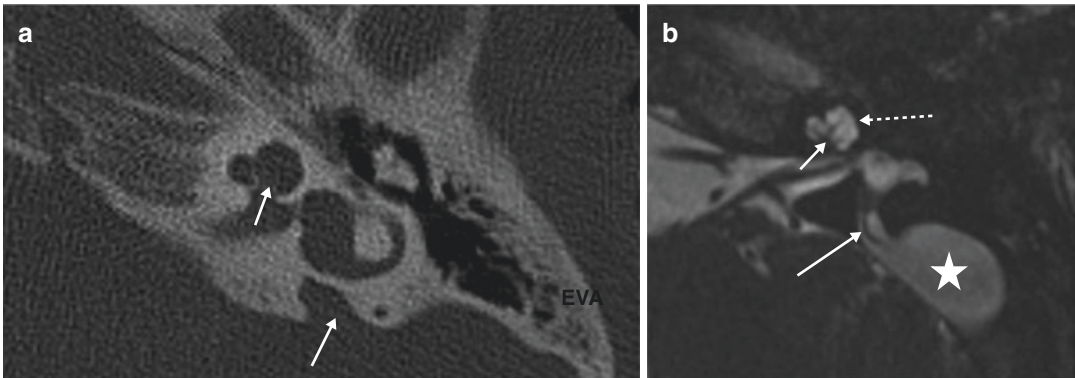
Computerized tomography (a) and magnetic resonance imaging (MRI) (b) findings in an incomplete partition type II patient with enlarged vestibular aqueduct
